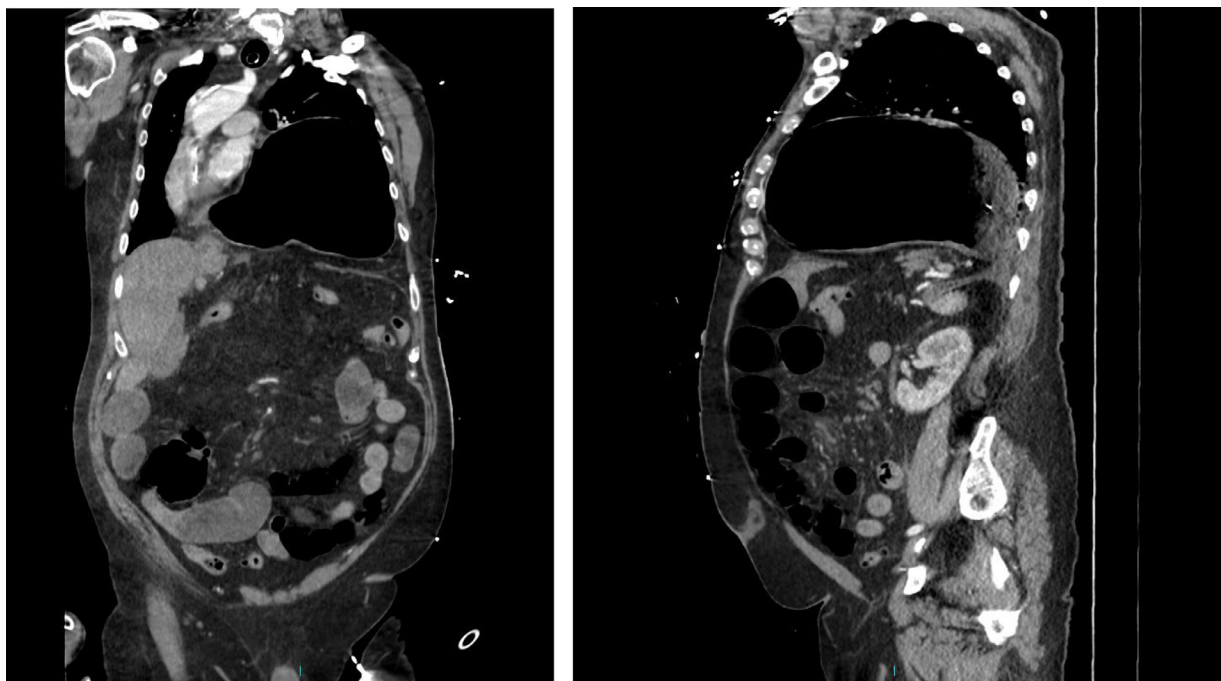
CT thorax, abdomen, and pelvis showing abdominal content in left hemithorax compressing the lungs bilaterally causing collapse and shifting the mediastinum to the right side.
